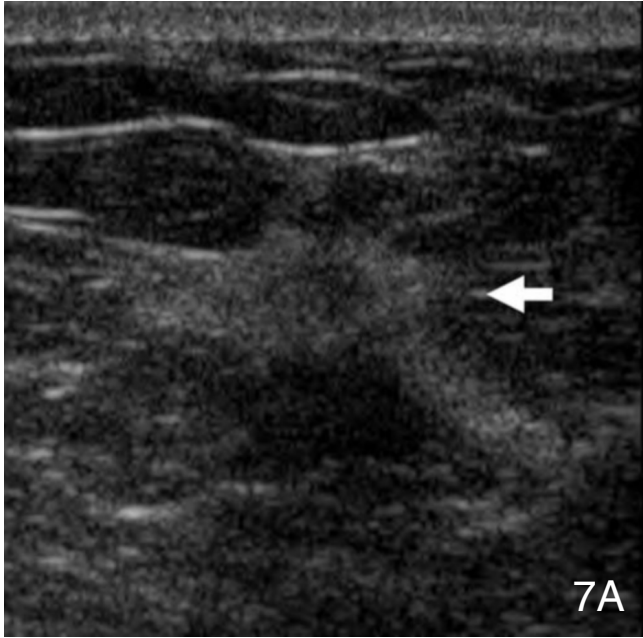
Ultrasound images of the left upper inner breast (all in the transverse plane) demonstrate: 7A) a 10 cm hypoechoic mass with a thick hyperechoic rim (arrow), 7B) ultrasound guided biopsy of the mass (arrow), and 7C) the mass (large arrow) following placement of a clip (small arrow) just adjacent to the mass
